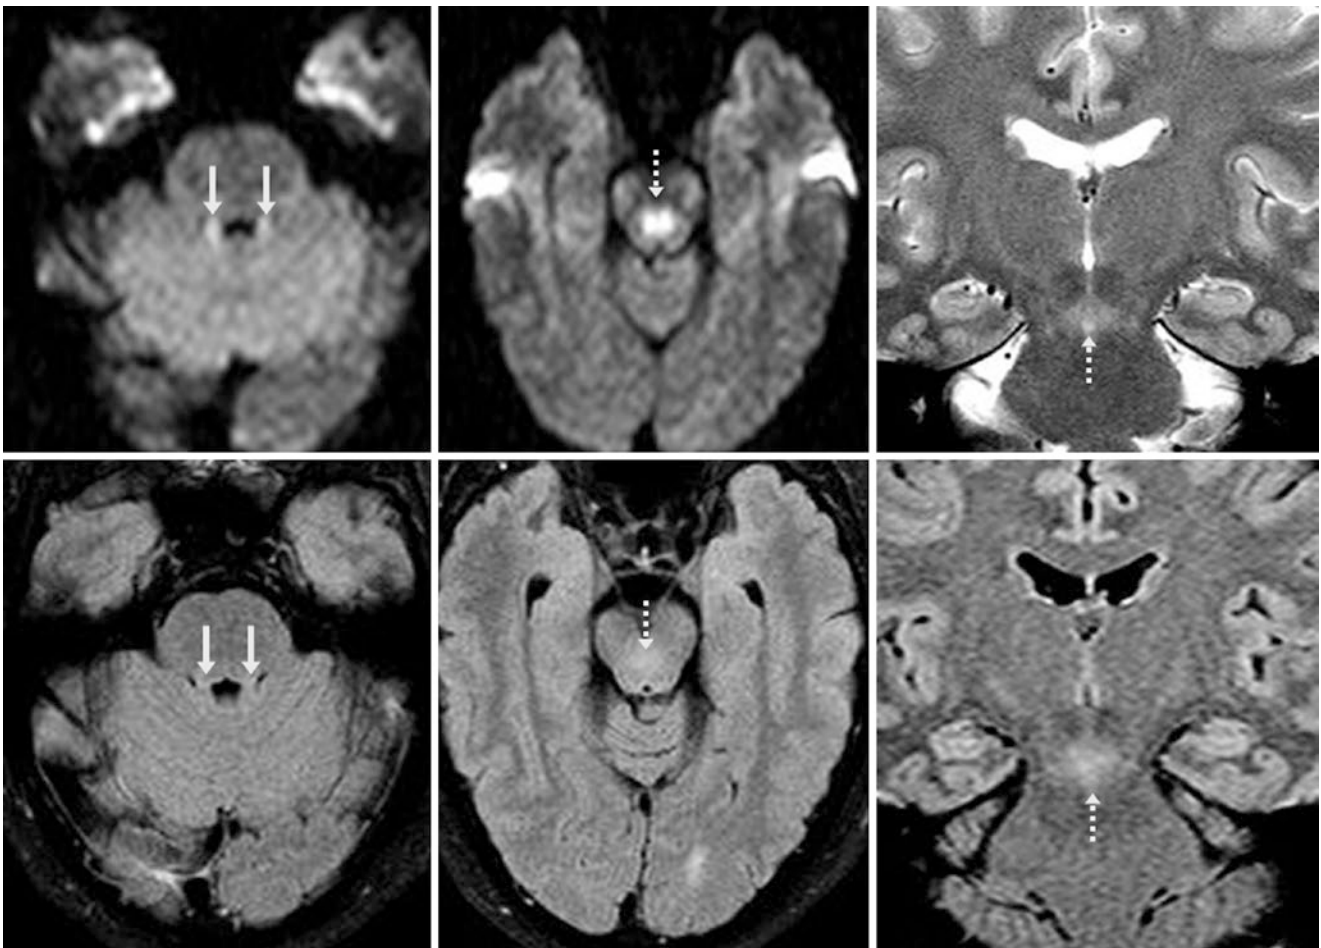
A 1.5 T MRI in a 35-year-old shows hyperintensity of the SCPs (*arrows*) and their decussation (DSCP) (*dotted arrows*) on DWI (*top left and top middle*), but without corresponding dark signal on the ADC map (*not shown*). The hyperintensity within the DSCP could
